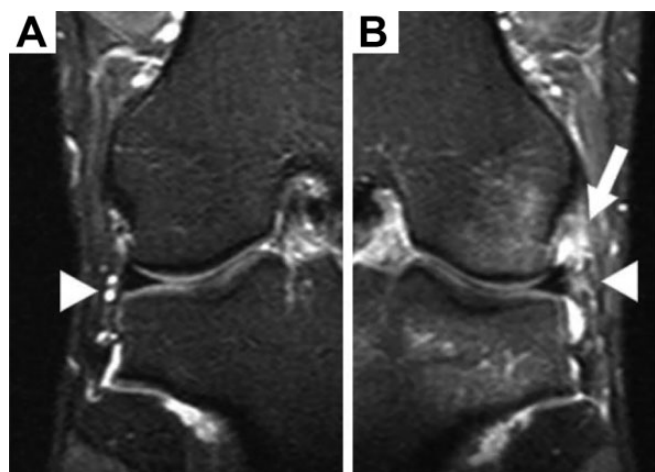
Coronal T2-weighted magnetic resonance images with fat saturation of the (A) uninjured right knee and (B) injured left knee of a patient. The arrow indicates the anterolateral ligament, and the arrowheads indicate the inferior lateral genicular vessels. MRI of the left knee demonstrated decreased thickness and increased signal of the anterolateral ligament compared with the contralateral normal ligament. Proximal fibers were also irregular. Note that the inferior lateral genicular vessels are asymmetric and are better depicted on the uninjured side (A).
